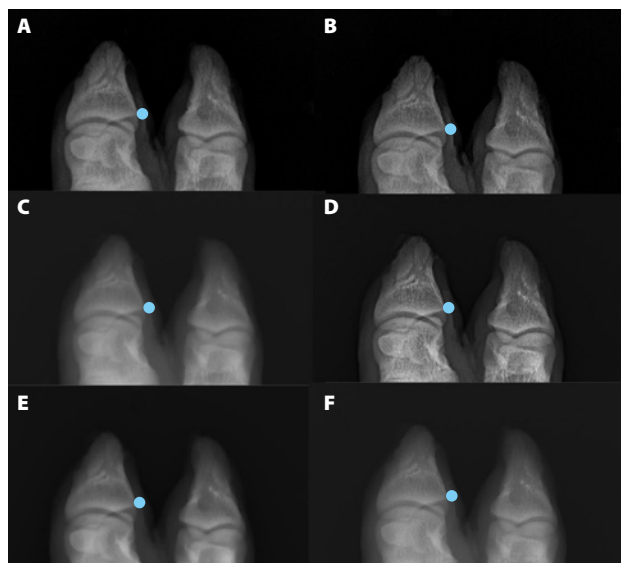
Cropped dorsoplantar images with the superficial 10 mm foreign body marked by a blue circle. A. Original computed radiography (CR) image with obvious density differences between structures, including foreign bodies (contrast), and noise. Trabecular pattern is visualized (spatial resolution). B. Sharpened CR image with more obvious density differences between structures and noise. Trabecular pattern is visualized better compared with image A. C. Original direct digital radiography (DDR) image with the lowest density differences between structures. Trabecular pattern is blurry without obvious noise. D. Edge-enhanced DDR image with density differences comparable to image B but with less noise and sharp trabecular pattern. E. Noise-reduced DDR image with no obvious noise and density differences higher than image C, but the trabecular pattern is blurry. F. Sharpened DDR image with no obvious noise and density differences higher than image C. Trabecular pattern is less blurry compared with image E. Images courtesy of the authors.
